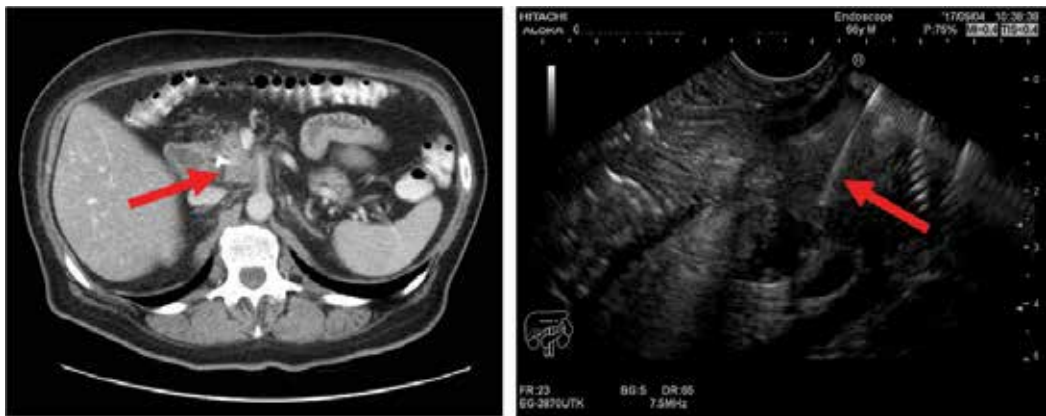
CT and corresponding EUS image of a pancreatic mass that proved to be pancreatic cancer.
